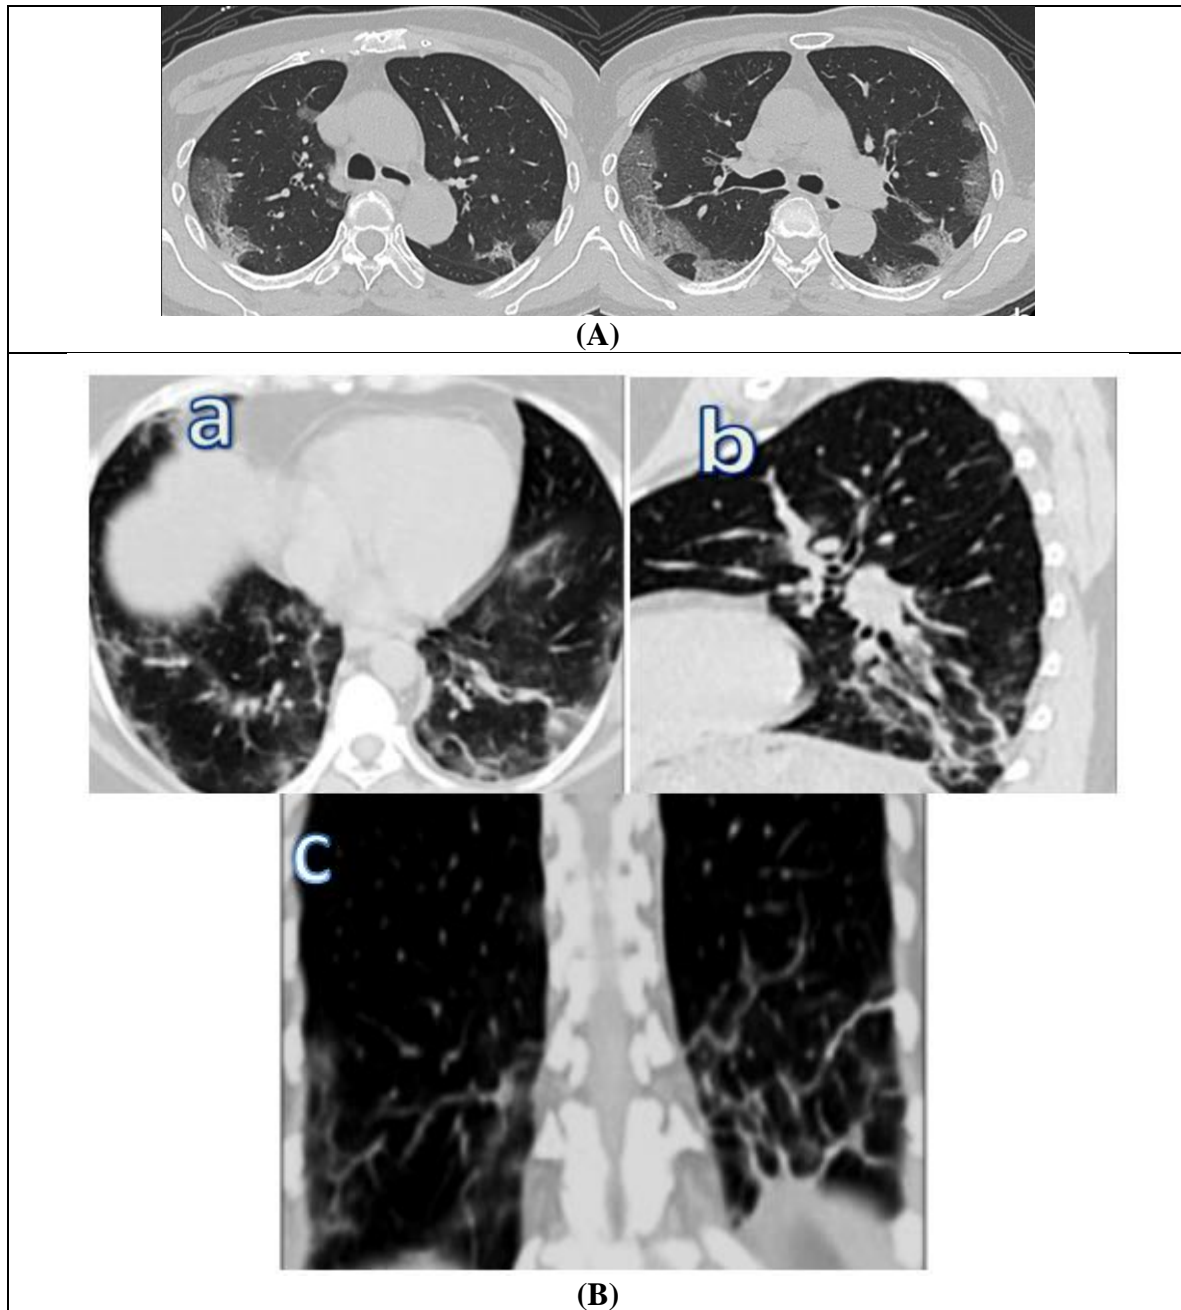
A) Initial MDCT findings: Axial MDCT signs of GGO, B) 3 m MDCT findings: CT-SS on was 13/ 25. MDCT chest (a, b, c) revealed bilateral lower lobar fibrotic changes.
